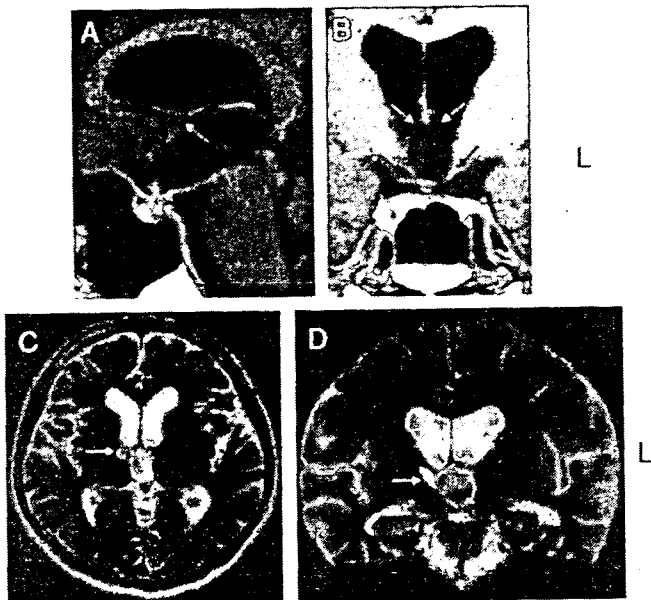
Sagittal (A) and coronal (B) T1-weighted, and axial (C) and coronal (D) T2-weighted brain MR images. MR images showed a cystic structure of residual craniopharyngioma in the third ventricle, which compressed the body of the fornix (dashed arrow) and reduced its thickness, and presumably induced the dilation of the anterior horns of the bilateral lateral ventricles (A, D). However, this structure had not enlarged after surgery. The bilateral crus of the fornix were thinned and partially destroyed on the left (dashed arrow) (B). Cystic change was detected in the right mammillary body and atrophy in the left (arrow) (B). No abnormal areas were detected in the thalamic structures, the medial temporal lobe, or the basal forebrain except for a small infarct in the right thalamic polar artery territory (white arrow) (C, D). L indicates left side.
